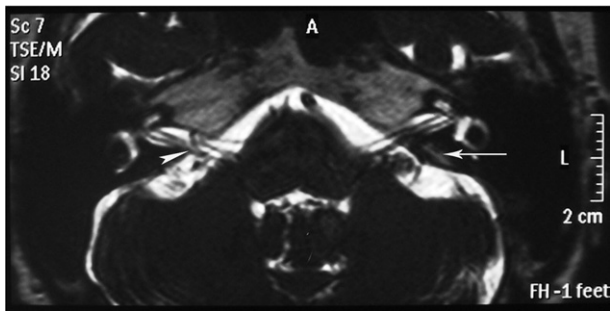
The dilatation of left vestibular aqueduct (arrow) and an AICA loop formation (arrowheads) in the right IAC of a 68-year-old woman complaining of vertigo were clearly observed on 3D drive T2-weighted MRI.
